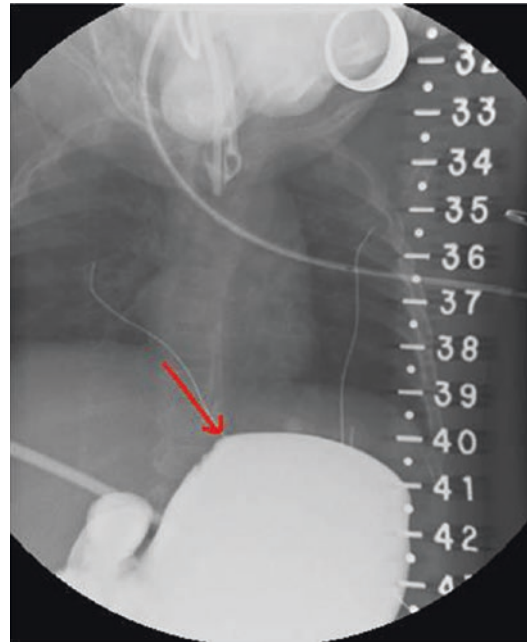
Radiograph showing a miniscule lower esophageal pouch
